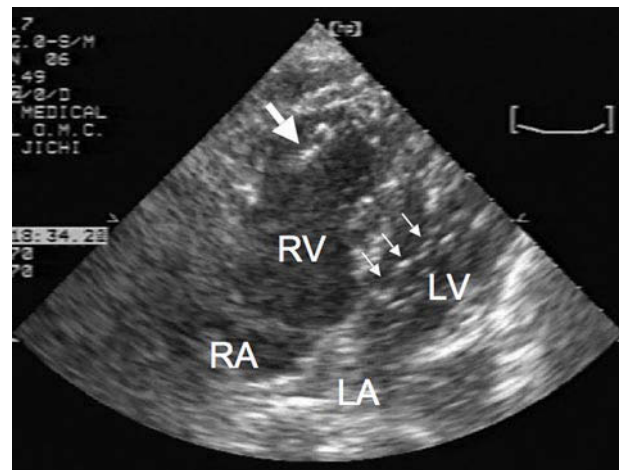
FIGURE Four chamber view of transthoracic echocardiography demonstrates a linear thrombus tethered to the right ventricular trabeculae (large arrow) and snowstorm-like bubbles in the left heart (small arrows). RV = right ventricle; RA = right atrium; LV = left ventricle; LA = left atrium.
